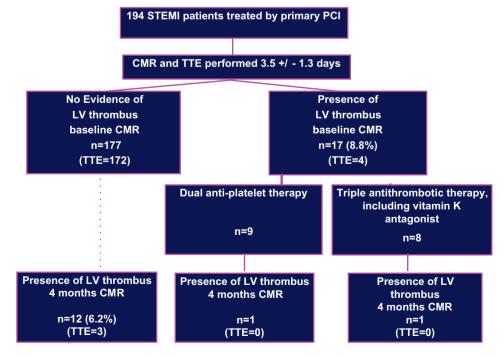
The course of left ventricular thrombus formation. CMR, cardiovascular magnetic resonance imaging; LV, left ventricular; PCI, percutaneous coronary intervention; TTE, transthoracic echocardiography; STEMI, ST-segment elevated myocardial infarction.
